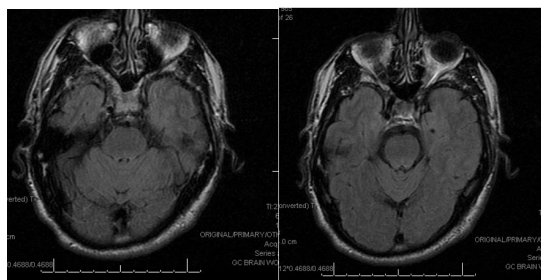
unremarkable T2 weighted MRI (A) and MRI flair (B) suggesting absence of concern for inflammatory, demyelinating etiology or infarcts.
